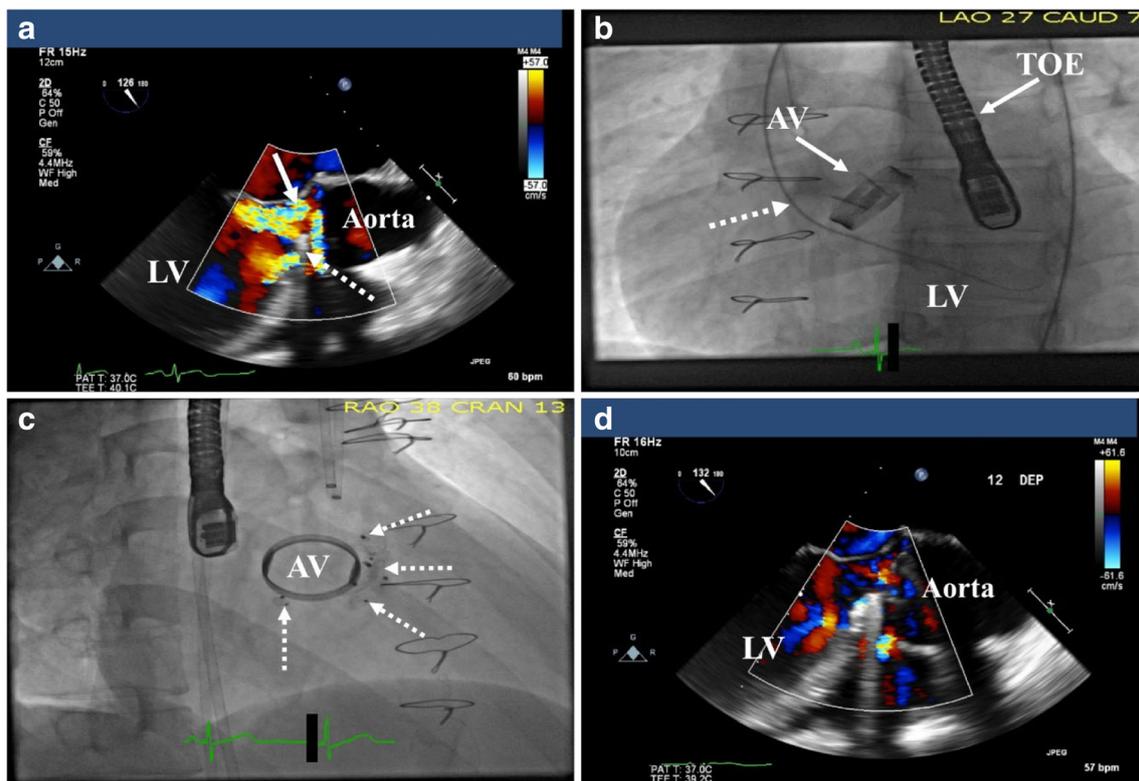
Percutaneous aortic valve paravalvular leak closure. a Baseline trans-oesophageal (TOE) (parasternal view) of the aortic valve (dashed arrow) with colour Doppler showing multiple paravalvular leaks (arrows) causing severe aortic regurgitation. Left ventricle (LV). b Fluoroscopic image of the aortic valve (AV) during PVL procedure showing catheter crossing the paravalvular defect (interrupted arrow) into the left ventricle
